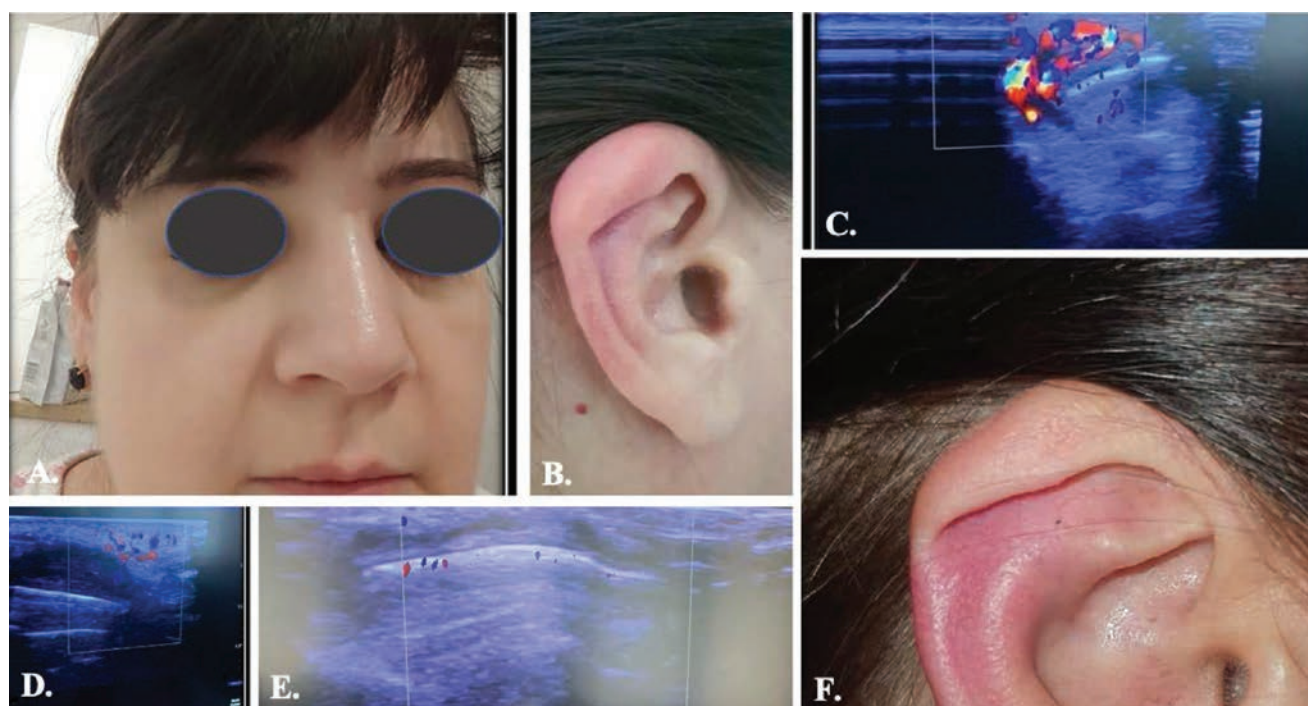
Figure A shows significant inflammation of the nasal bridge, figures B and F show inflammation of the upper part of both ears; figures C and D reflect the ultrasound examination with intense Doppler signal in both ear cartilages and figure E is a Doppler ultrasound of the nasal bridge
